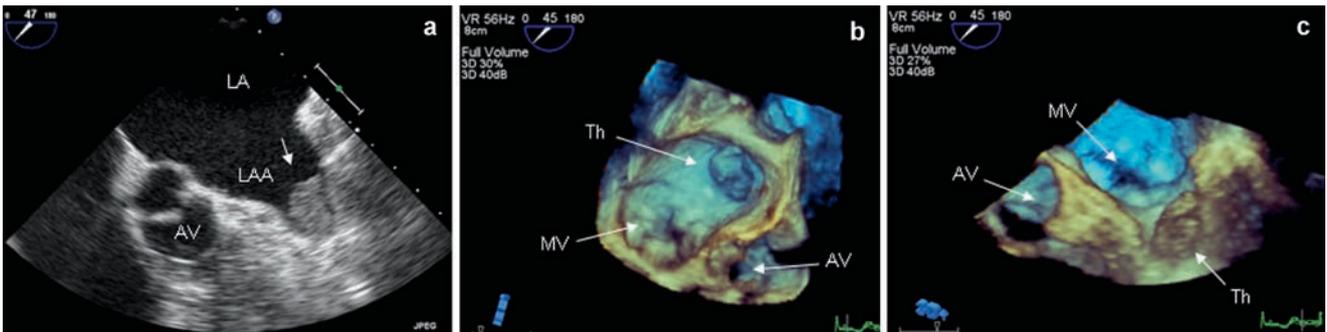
Cardiac thrombus in the left atrial appendage in a 74-year-old male patient with moderate-severe mitral stenosis and dilated left atrium. Trans-oesophageal echocardiographic imaging in 2D mode (a) shows a 1.0 × 1.9 cm large isodense, slightly mobile thrombus (*arrow*) in the left atrial appendage (LAA). Real-time 3D imaging
